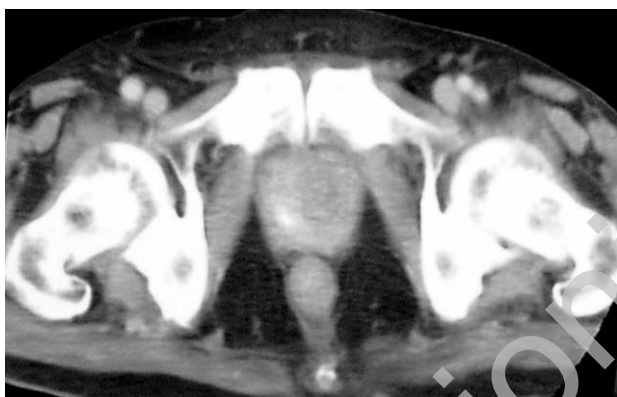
Contrast-enhanced CT of the lesser pelvis shows no extraprostatic spread of the disease. Prostatic calcifications and the TUR cavity can be identified.
